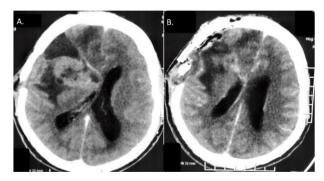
'A' is the preoperative MRI of a large recurrent glioma grade III. 'B' shows the postoperative scan of the patient. The dura was opened in a staged manner with the tumor resection to tackle the bulging. The mass could be excised subtotal due to its invasion into the surrounding eloquent region.
